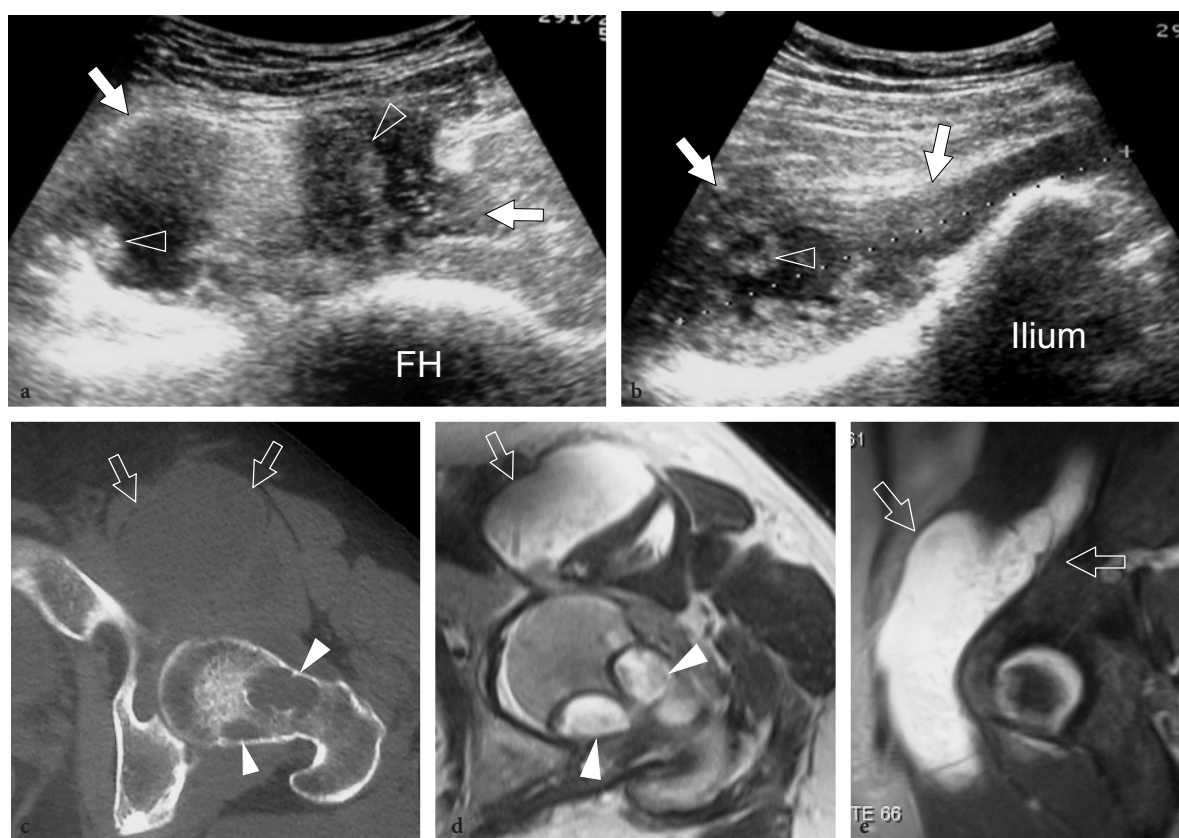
Iliopsoas bursitis in patient with advanced rheumatoid arthritis. a,b Transverse oblique 3.5 MHz US images obtained a at the level of the femoral head (FH) and b over the ilium. The iliopsoas bursa (arrows) appears markedly swollen and contains anechoic effusion and echogenic synovial folds (arrowheads) representing rheumatoid pannus. c Corresponding transverse CT image confirms bursal distention by its hypodense content. Large marginal erosions (arrowheads) can be appreciated as associated findings in the femur. d Transverse T2-weighted and e sagittal fast-STIR MR images confirm the US findings. In e, observe the bursa extending within the pelvis (arrows)
